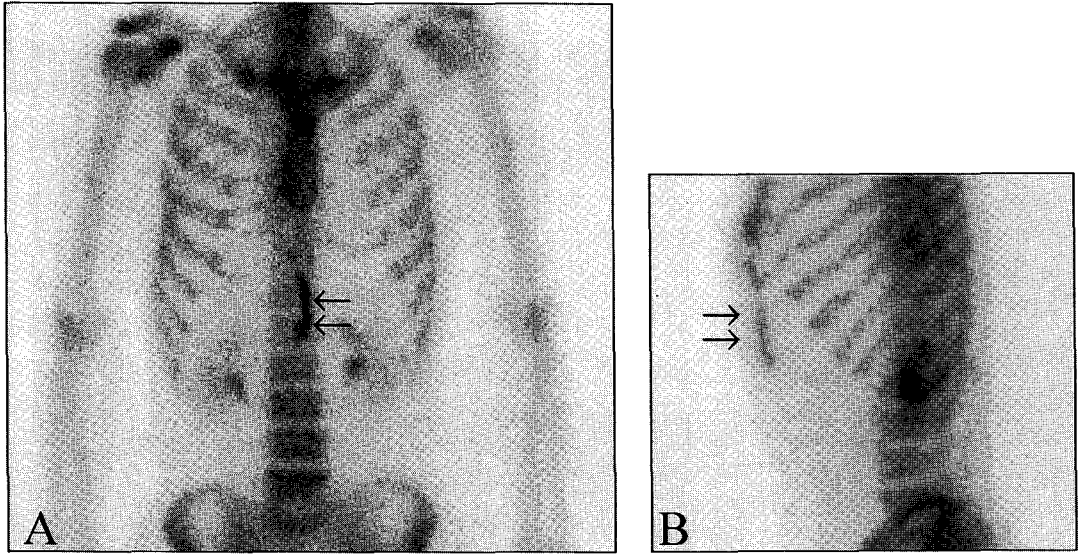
The anterior image (A) of Tc-99m MDP bone scintigraphy shows an unusual linear increased uptake along the midline of the upper abdomen that corresponded to the skin incision for subtotal gastrectomy. The left lateral view (B) obtained additionally to differentiate any other abnormal uptake demonstrates that the unusual uptake was superficial in healing surgical scar such as keloid.
